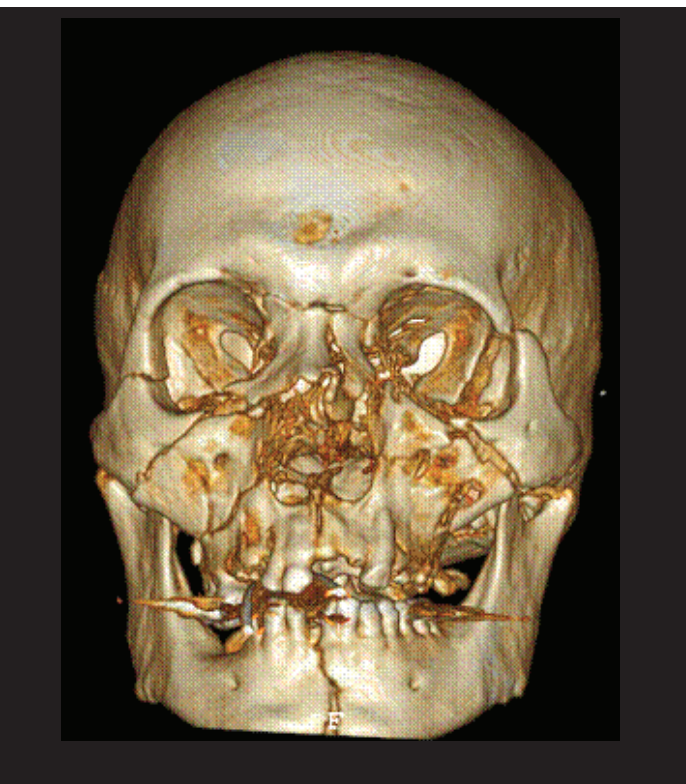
Modern CT scanning significantly aids treatment planning of maxillofacial injuries
